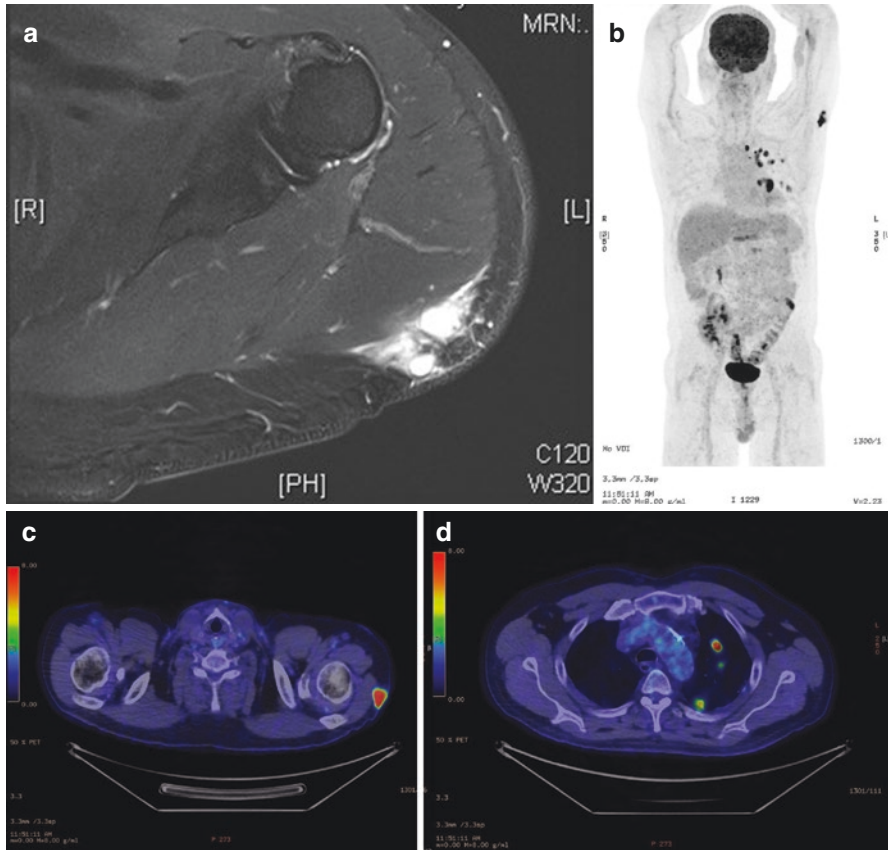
(a) A 62-year-old Vietnamese male presented with a firm subcutaneous lump over the posterior aspect of the left shoulder. T2-weighted fat-saturated image shows an ill-defined solid subcutaneous mass ? soft tissue sarcoma. (b) F18-FDG MIP image demonstrates that the left shoulder mass is tracer avid with a number of PET-avid masses within the left lung raising the possibility of associated metastatic disease. (c) Fused axial PET/CT images confirming the index mass is metabolically active. (d) PET-positive lung parenchymal masses. Percutaneous biopsy of the left shoulder mass demonstrated *Cryptococcus neoformans* with the cavitating lung lesions consistent with associated lung parenchymal involvement
